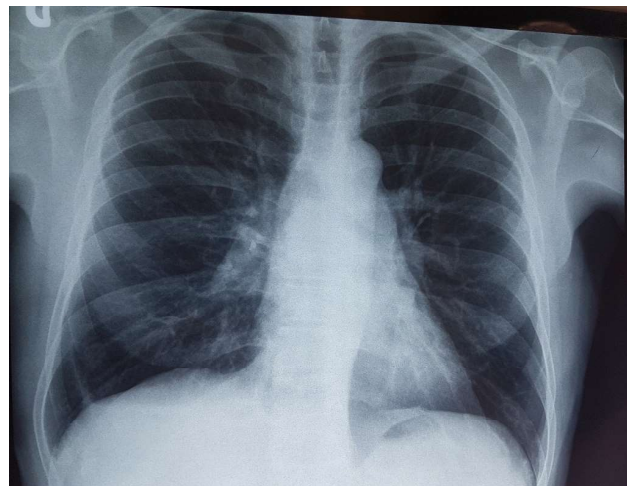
Chest X-ray of the 64-year-old patient presented with MDR-TB
